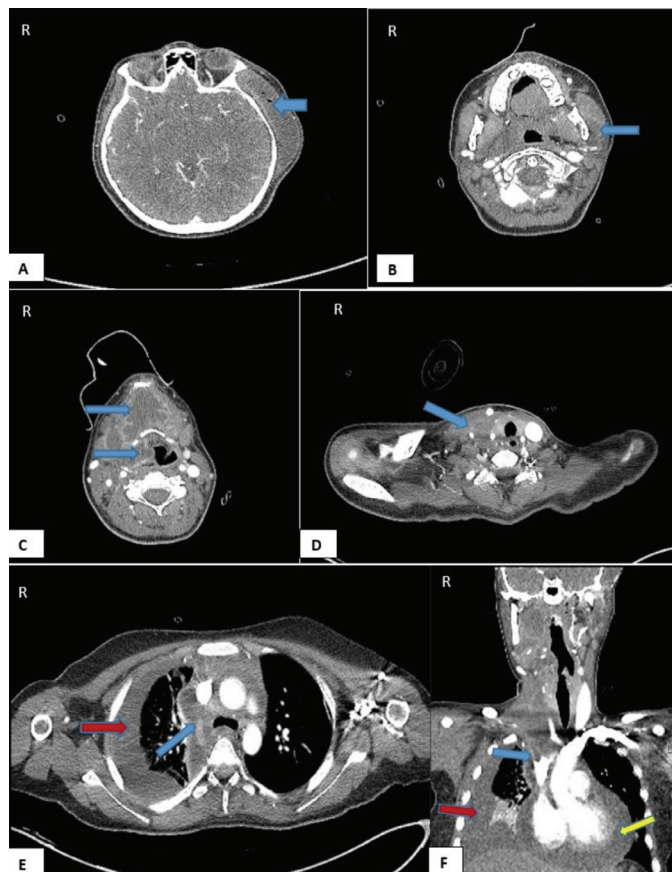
Abscess localization and accompanying findings in computed tomography. Abscess obliterating the aryepiglottic fossa is seen in the left temporal region paracalvarial area (A; blue arrow), around the left mandibular ramus (B; blue arrow), and in the right parapharyngeal area. The collection area crosses the submental and submandibular areas in a horseshoe shape (C; blue arrows) and deviates the trachea slightly to the left on the right side (D; blue arrow). The abscess area extends to the mediastinal area between the jugular vein and the carotid artery on the right side (E; blue arrow). Compression-related thinning in the right jugular vein calibration, intraluminal thrombus image in the innominate vein (F; blue arrow). Pericardial effusion (F; yellow arrow), pleural effusion and atelectatic lung fields (E, F; red arrow) accompanying abscess
